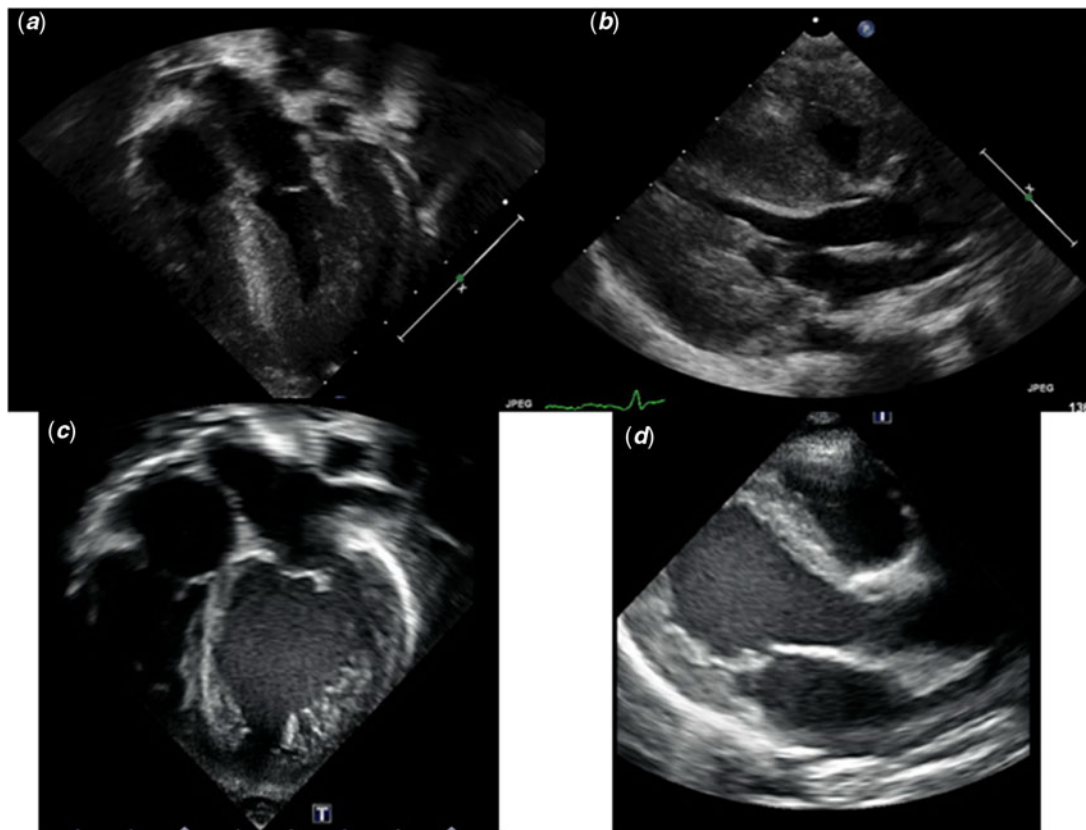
2D-echocardiogram images ((a) apical view and (b) parasternal view) demonstrating moderate biventricular hypertrophy. LVIDd 2 cm (z score 1.2), LVPWd 0.48 cm (z score 2.9), IVSd 0.56 cm (z score 2.1), ejection fraction 49%. Follow-up images ((c) apical view and (d) parasternal view) at 17 months of age with biweekly enzyme replacement therapy demonstrating resolution of biventricular hypertrophy. LVIDd 3.1 cm (z score 1.7), LVPWd 0.39 cm (z score 0.35), IVSd 0.43 cm (z score 0.00), ejection fraction 64%. LVIDd = left ventricular internal dimension at end-diastole; LVPWd = left ventricular posterior wall thickness at end diastole; IVSd = interventricular septum thickness at end diastole; EF = ejection fraction. The above images were captured during diastole.
